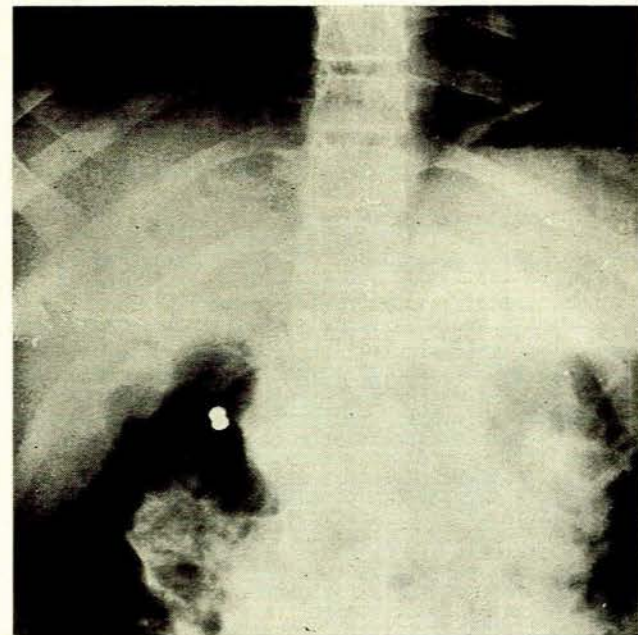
Erect abdominal radiograph showing pellet to right of midline.
